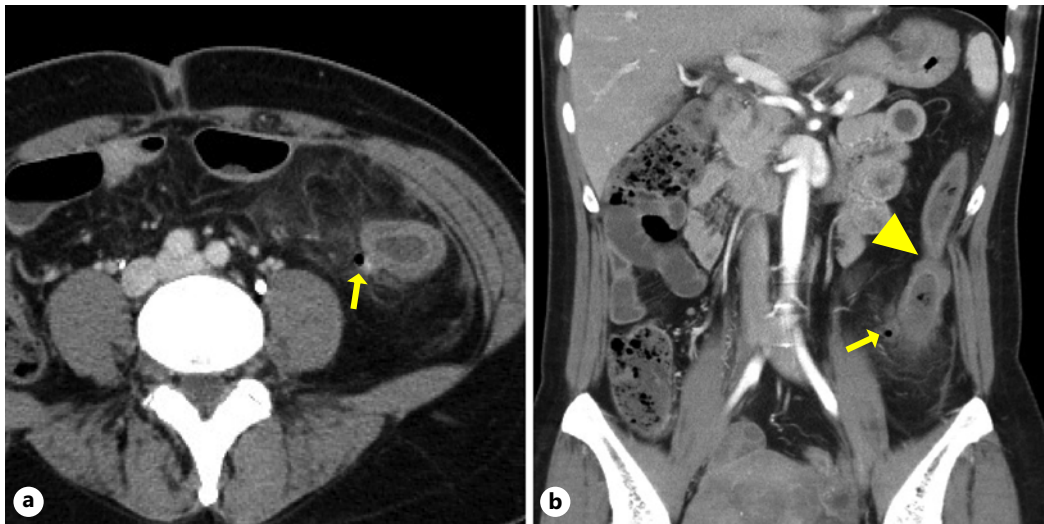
Contrast-enhanced computed tomography findings. In the horizontal (a) and coronal (b) sections, thickening of the wall of the descending colon and an increase in fat concentration around the wall are observed, and a small amount of air is observed in the mesentery near the intestinal wall (arrow). In the coronal section (b), a descending colon stricture was observed (arrowhead) where endoscopic balloon dilation was performed.
